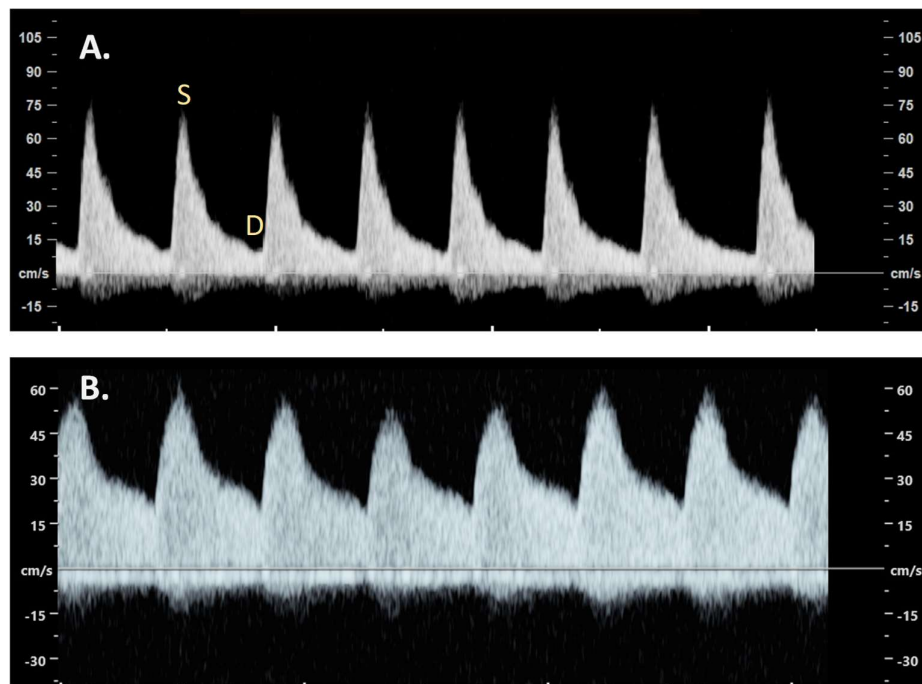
A. Normal Doppler waveform of the middle cerebral artery imaged with contemporary ultrasound equipment. S is the peak systolic velocity and D is the least diastolic velocity. B. Doppler waveform of the middle cerebral artery demonstrating increased end diastolic velocity. Images produced by D Paoletti.
